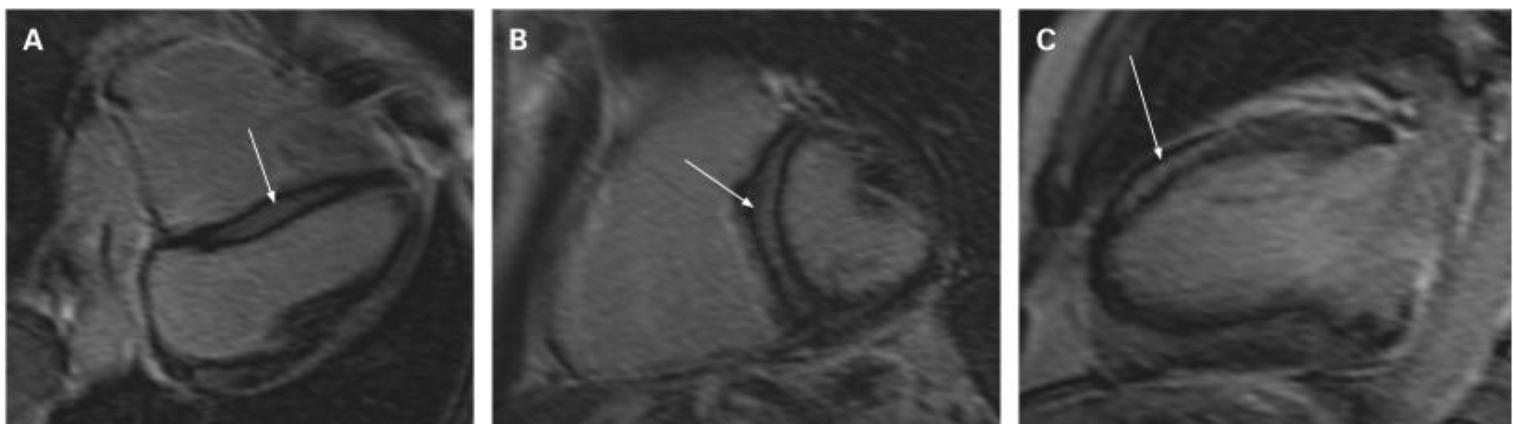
Mid-wall linear late enhancement (arrows) in anteroseptal location assessed by delayed enhancement sequence 10 min after Gd-DTPA injection on an MRI 1.5 Tesla scan. (A) Four chambers; (B) short axis; (C) long axis.
